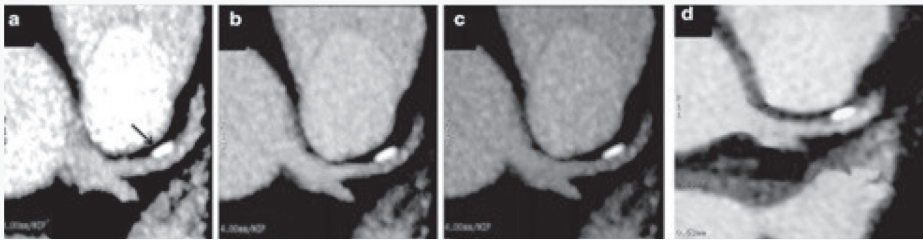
Dual-energy CT: atheroma with calcification proximal to LAD, large plaque at 40keV (a), a smaller plaque at 60keV (b), and atheroma further reduced in size at 80keV (c). On one-energy CT: atheroma with calcifications equal in size to that of 60keV (d). (Source: Carrascosa PM, Cury RC. Dual-Energy CT in Cardiovascular Imaging. 2015:173-230.)(15)
